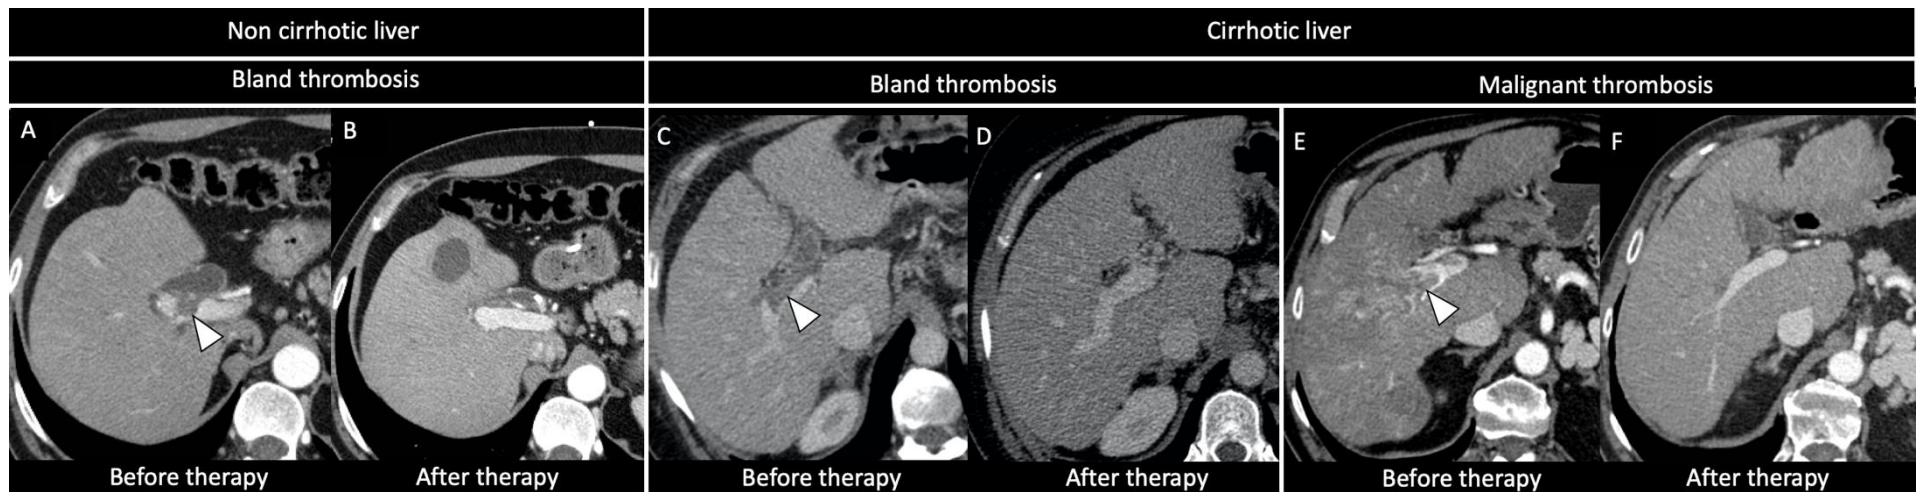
a and b: 45-year-old male-to-female transgender, in estrogenic hormone therapy with cholecystitis and bland thrombus. (a) Contrast enhanced CT on arterial phase shows a bland thrombus (arrow) in the portal vein that (b) completely regressed after anticoagulant therapy; of note, patient developed a liver abscess in segment 4 in the interval time. c and d: 56-year-old cirrhotic man with bland thrombus. (c) Contrast enhanced CT on portal venous phase shows a bland thrombus (arrow) in the portal vein that (d) completely regressed after anticoagulant therapy. e and f: 72-year-old cirrhotic man with infiltrative HCC. (e) Contrast enhanced CT on arterial phase shows an infiltrative HCC with portal vein tumor invasion (arrow) that (f) regressed after therapy with sorafenib.
